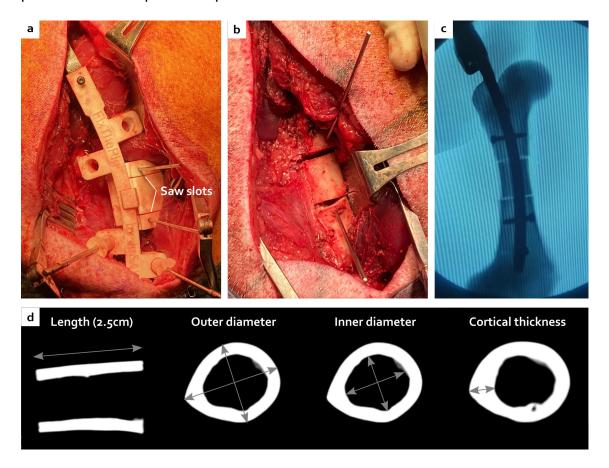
Creation of the critical-size bone defect with the ancillary and the cutting guide (a) leading to a centred ostectomy with reproducible morphology visible during the surgery (b), under fluoroscopy (c) and after CT scan analyses (d).
